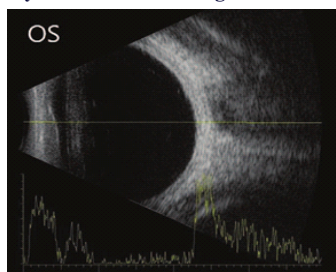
Left eye ultrasound showing choroidal thickening.
